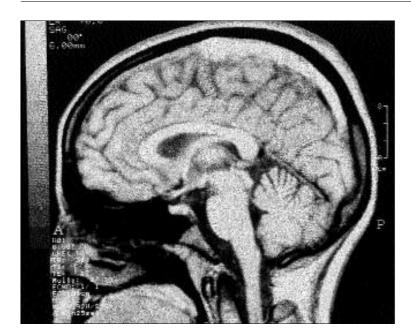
Cerebral MRI with gadolinium enhancement. T1weighted sagittal images showing a subacute thrombus in the posterior and middle thirds of the superior sagittal sinus
